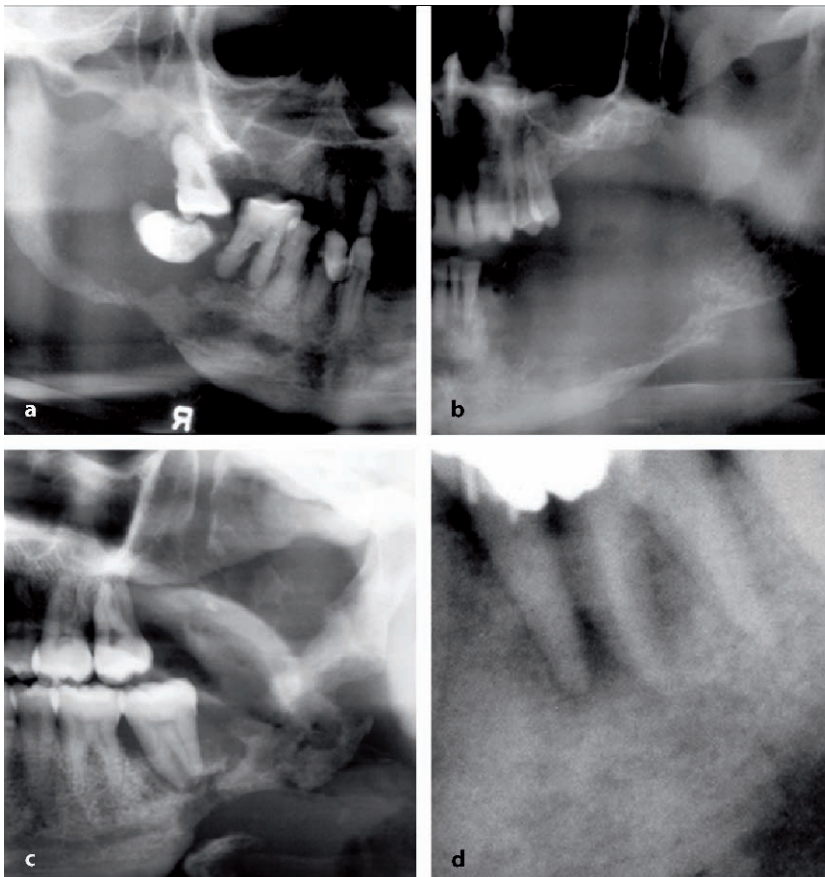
Panoramic radiograph details. a, b Invasion of the mandible from intraoral cancer. Saucerization has extended almost to the lower border of the mandible in these cases, and both mandibles have undergone pathological fracture. c, d Malignancies central within the mandible. Case c also shows a pathological fracture and involvement of the mandibular canal. Case (d) is metastatic breast cancer and demonstrates irregular erosion arising centrally within the mandible
